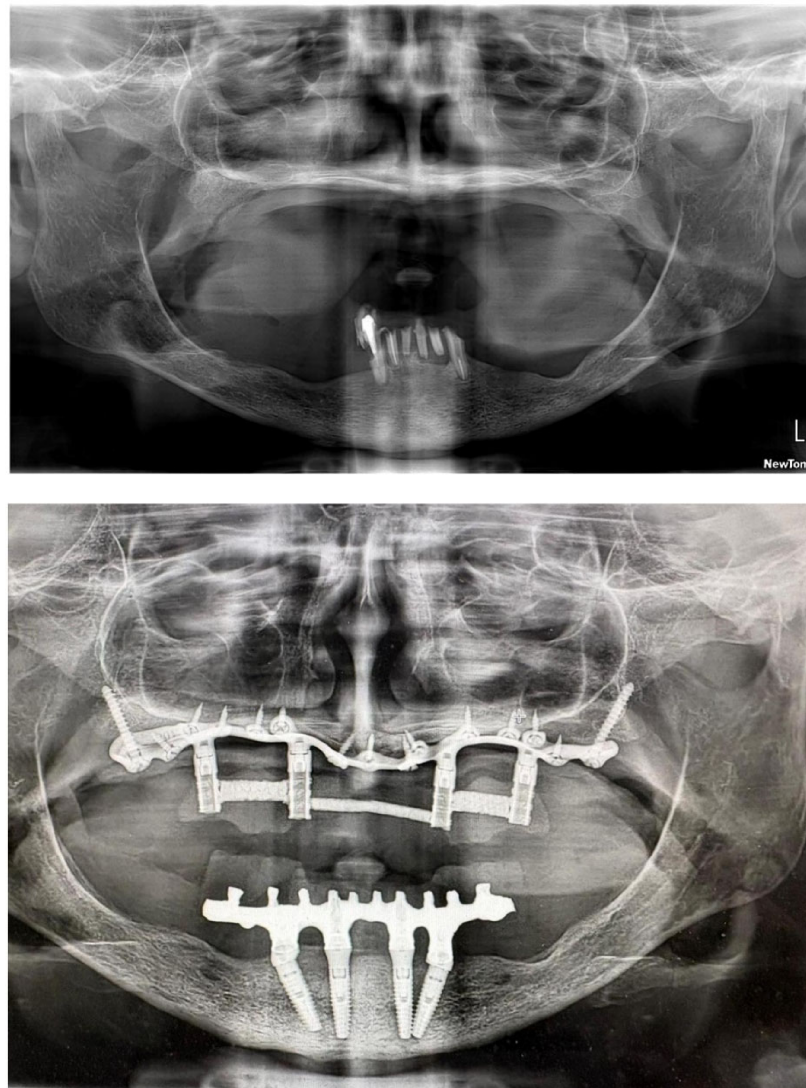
Comparison of preoperative and postoperative panoramic radiographs.
